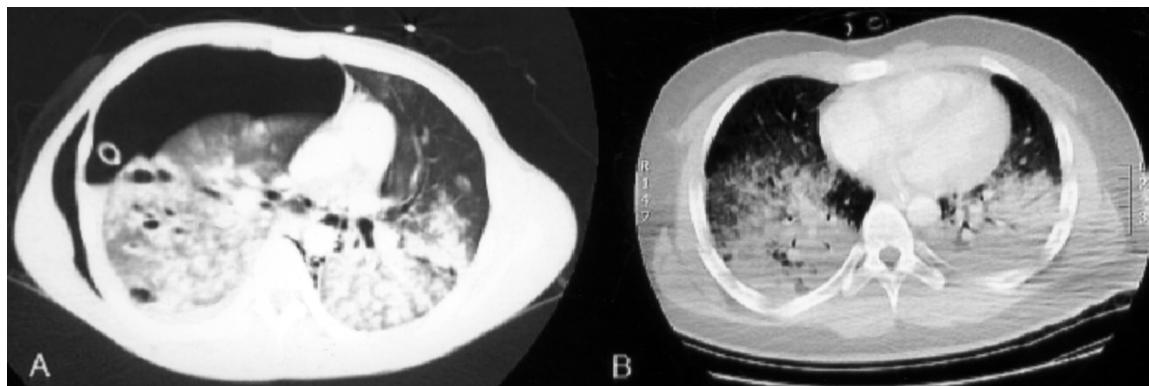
A. The chest CT of case 1 showed right hemo-pneumothorax and bilateral lower lung consolidations. B. The chest CT of case 2 also showed bilateral lower lung consolidations.
